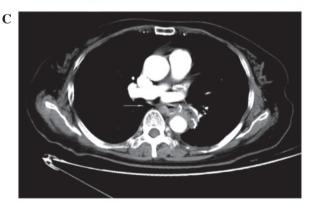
(A) Upper gastrointestinal barium esophagogram findings showing a circular defect in the lower esophagus from February 8, 2013. (B) Pre-surgical computed tomography (CT) scan showing the thickness of the middle esophagus wall, conducted on February 16, 2013. (C) Post-surgical CT scan demonstrating no thickness of the middle esophagus wall, conducted on August 14, 2013.
